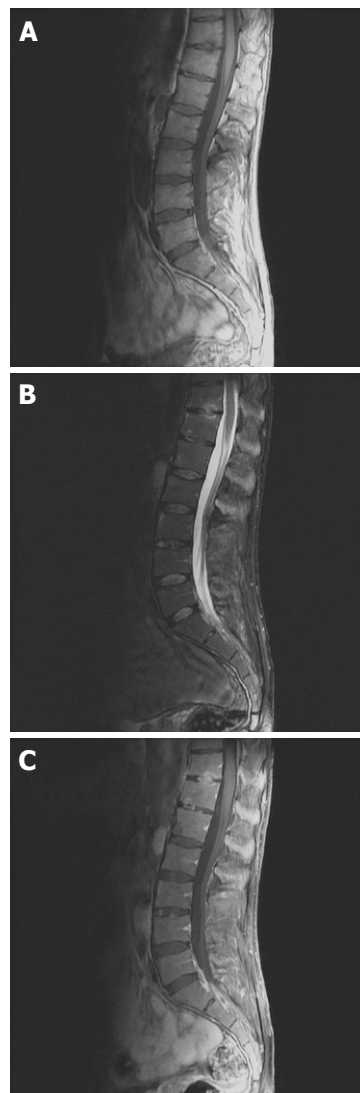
Inflammatory changes and structural damage on spinal magnetic resonance imaging. A: T1-weighted fast spin echo sagittal magnetic resonance scan of the lumbar spine shows hypointense lesion on end plates of thoracic 11 and 12 vertebrae; B: T2-weighted fat suppressed sagittal image shows hyperintense signals at the lesion and also at the upper anterior of the L3 and lower anterior of the L2 vertebra; C: T1-weighted post-contrast images shows enhancement of the contrast media at the borders of the lesion revealing acute spondylodiscitis.
